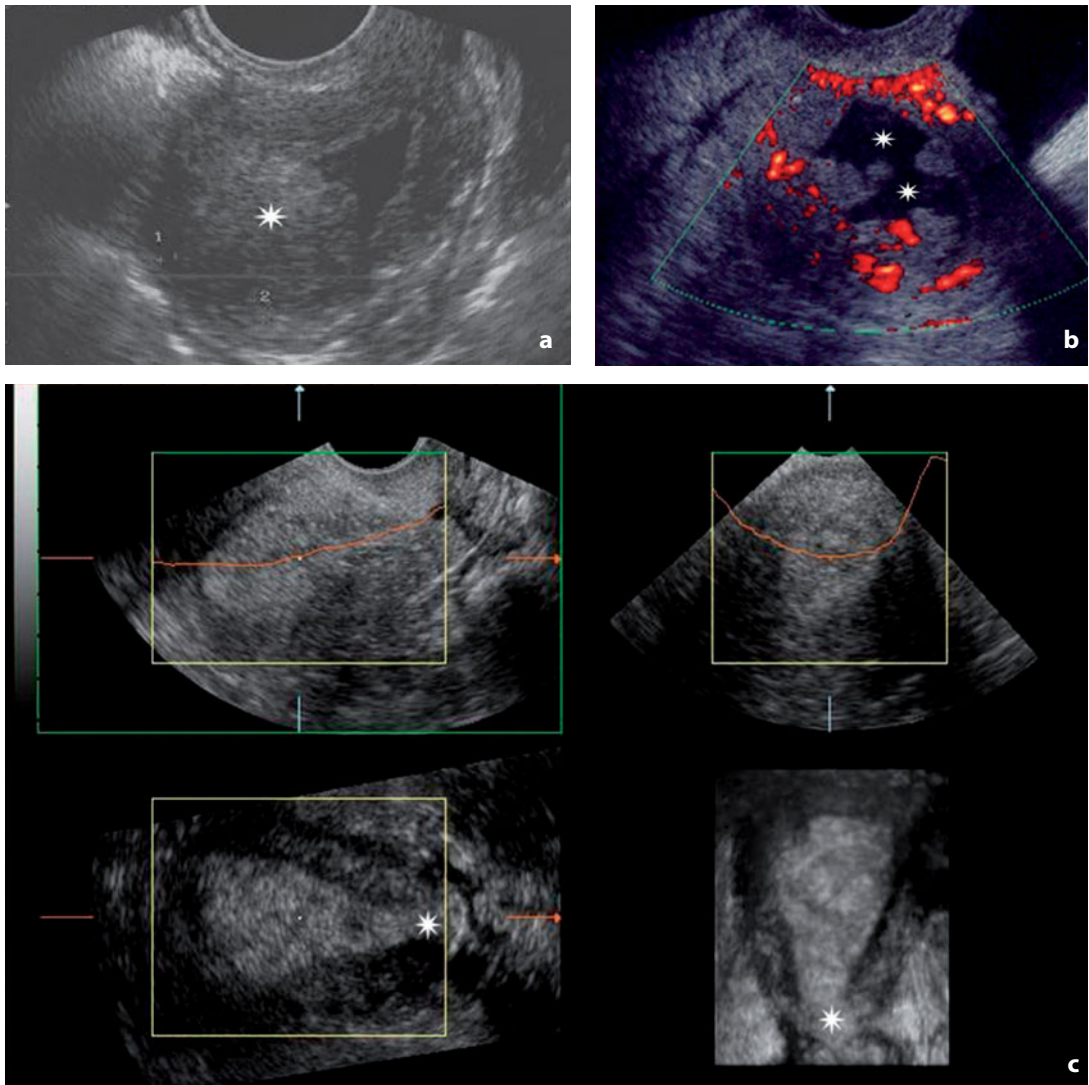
Ultrasonography. Carcinoma of the endometrium. a Stage IC. The tumor (*asterisk*) focally invades the external half of the myometrium. b Stage IC. Different patient. Invasion of the entire thickness of the myometrium. The endometrial cavity (*asterisks*) has irregular and fimbriated margins. c Stage II. The tumor extends to the cervical canal (*asterisk*), with invasion of the cervical stroma. The findings are well documented in the 3D reconstruction
